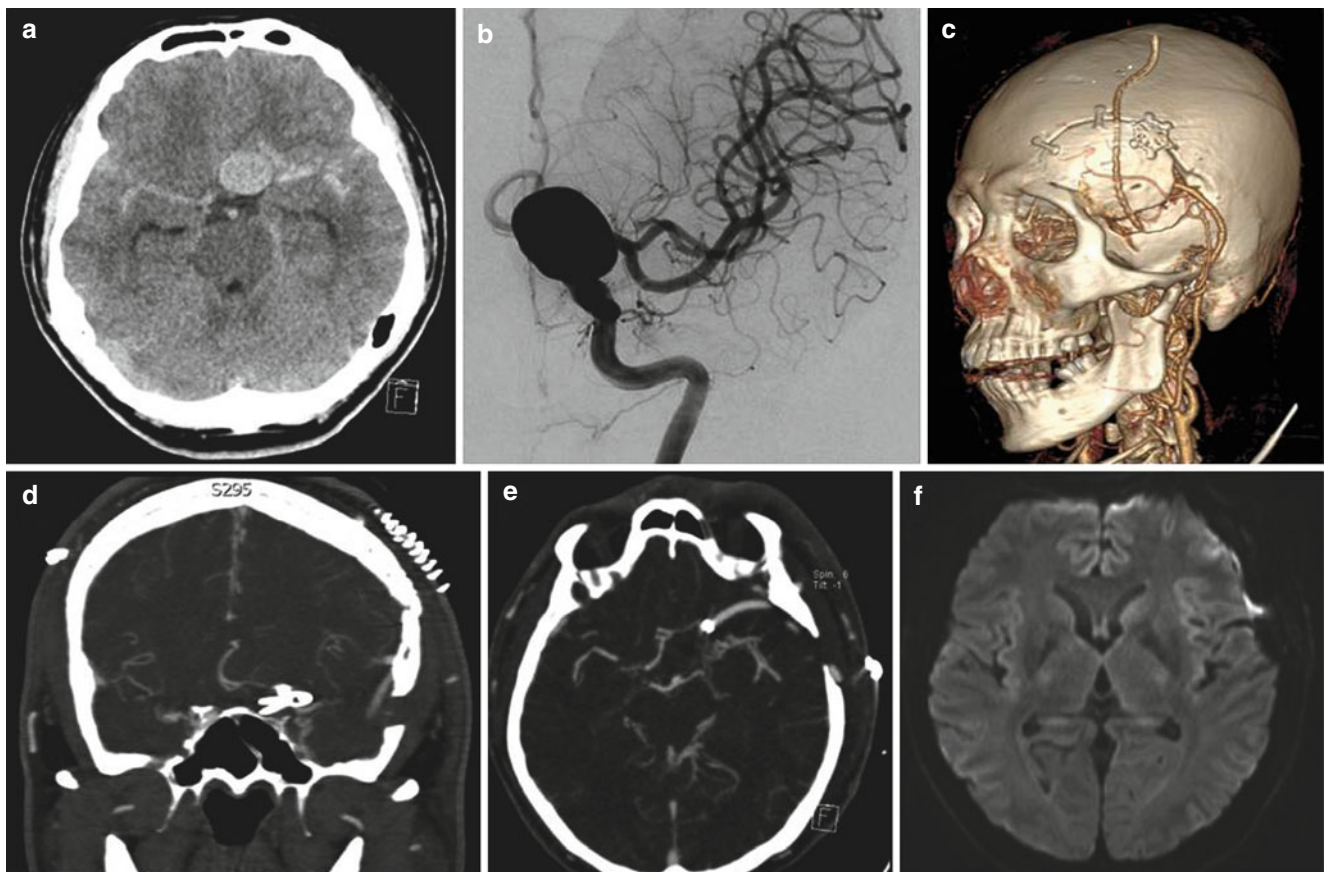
Axial CT (a) and DSA (b) showing ruptured ICA aneurysm. Postoperative 3-D reconstruction CTA (c) showing ELANA bypass and axial (d) and coronal CTA (e) indicating trapped aneurysm. Postoperative diffusion MRI (f) showed no diffusion restriction
